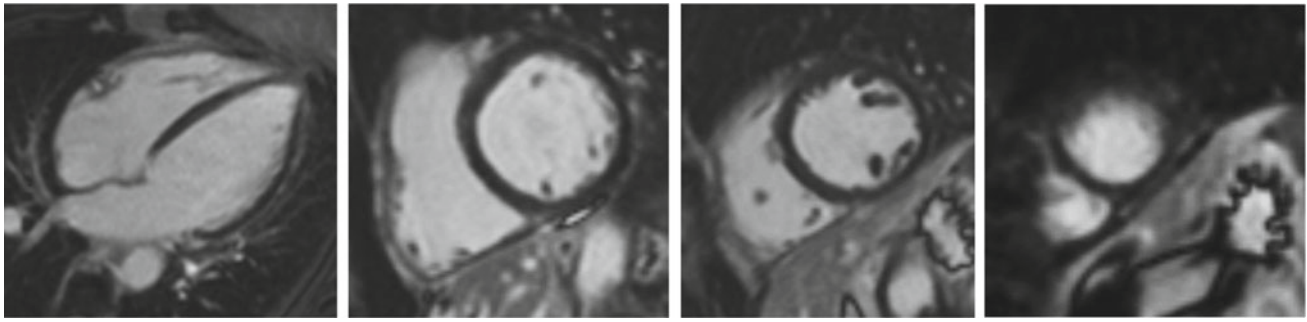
Contrast cardiac MRI, LV 4-chamber long axis, LV short axes (basal, medium, apex levels), no late gadolinium hyperenhancement or scarring
